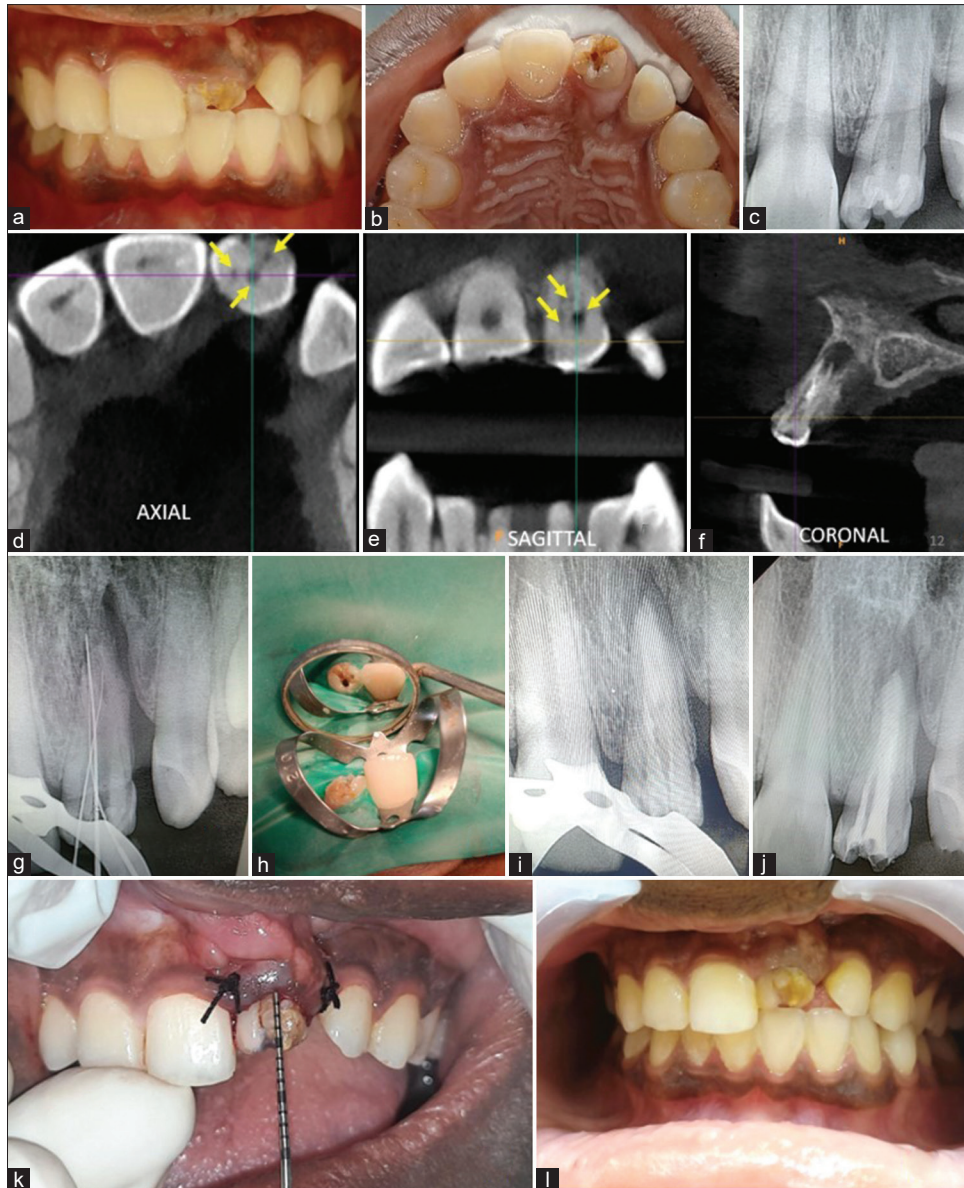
(a-c) Preoperative images, (d-f) cone-beam computed tomography images indicating the three canals, merging into one and an open apex, (g and h) access opening and working length determination, (i) mineral trioxide aggregate apexification (j) obturation (k and l) crown lengthening surgery with osseous reduction (immediate, after 6 weeks) (yellow arrows denote the three separate canals within a single root)
